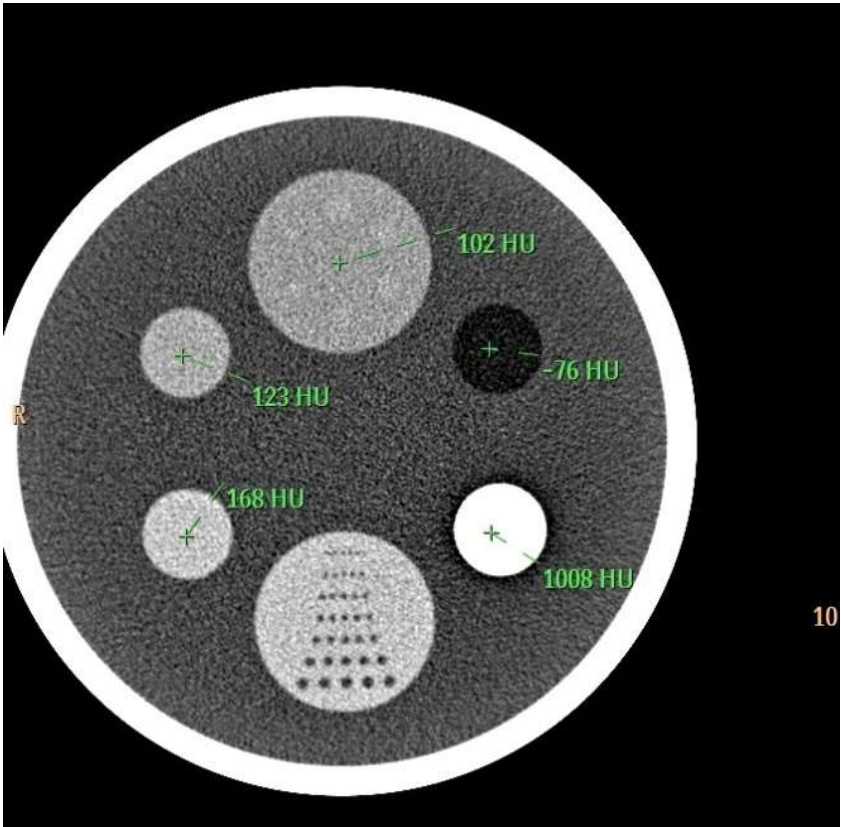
CT Number Linearity
